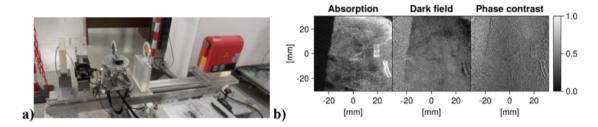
a) 4D GRAPH-X: left to right, the detector, the 3 gratings, and the microfocus X-ray source.
